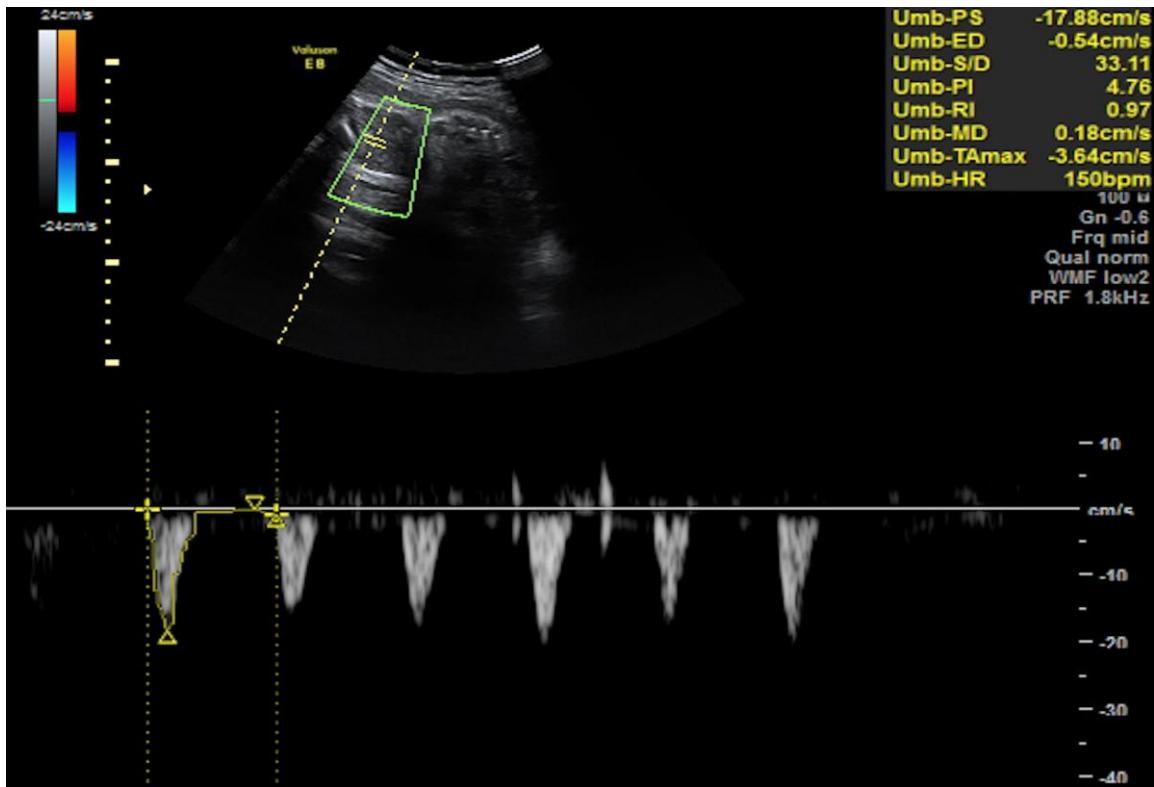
Doppler measurement at 39+0 weeks of normal TA-PI (measured manually).
